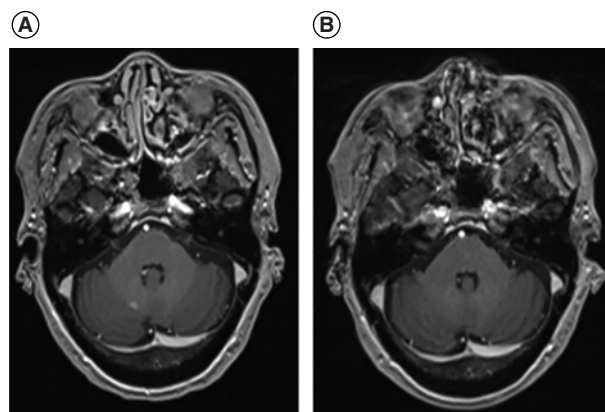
Brain MRIs of first relapse of primary central nervous system lymphoma and its resolution after temozolomide+rituximab treatment. (A) Brain MRI showed first relapse at 11 months after completion of high dose-methotrexate (HD-MTX) induction therapy, 17 months after diagnosis of primary central nervous system lymphoma. The recurrent lymphoma was seen at right cerebellum on the post-contrast T1 image. (B) Brain MRI showed resolution of 1st relapsed lymphoma on the post-contrast T1 image at right cerebellum after 1 cycle (4 weeks) of temozolomide (TMZ) and rituximab (RTX) therapy.
